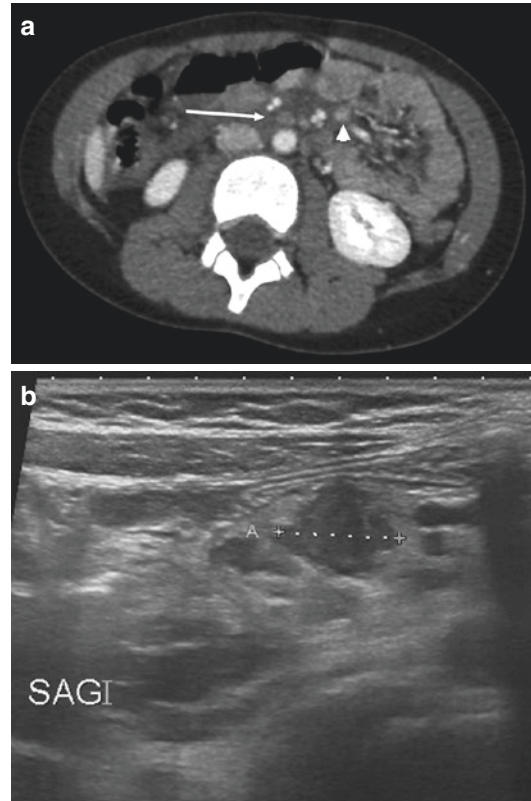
Six year old girl. Epigastric trauma with normal initial US but abdominal contracture. (a) CT with contrast shows mesenteric infiltration (*white arrow*) with a little active bleeding (*white arrow head*). (b) Control US shows mesenteric hematoma treated conservatory with success
